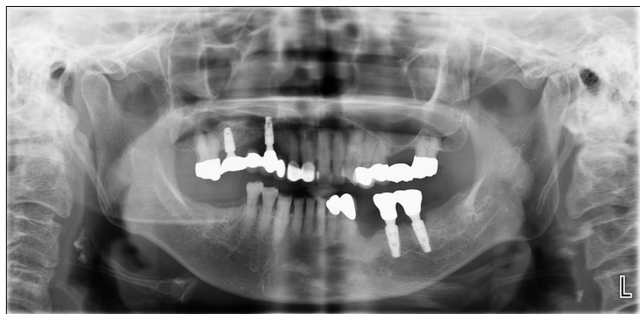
Panoramic radiograph (case 1) showing alveolar bone loss in the left upper and lower posterior areas. No pathologies that could cause pain were identified.
